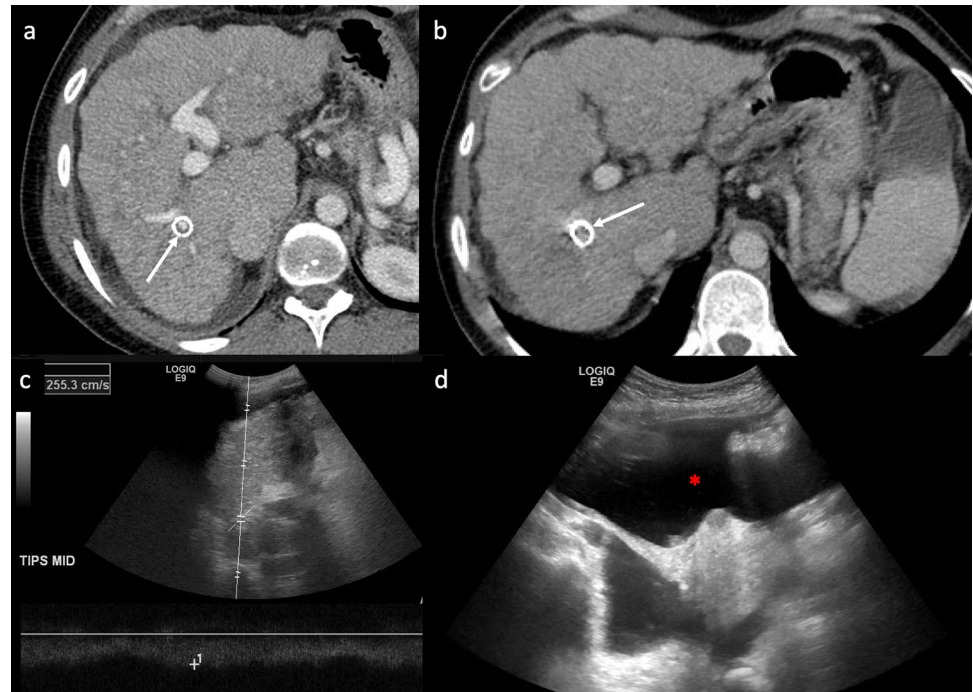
TIPS dysfunction. Axial contrast-enhanced CT images (a, b) in a cirrhotic patient show TIPS occlusion as hypodensity in the stent lumen (arrows). Axial contrast-enhanced MR image (c) shows stent
